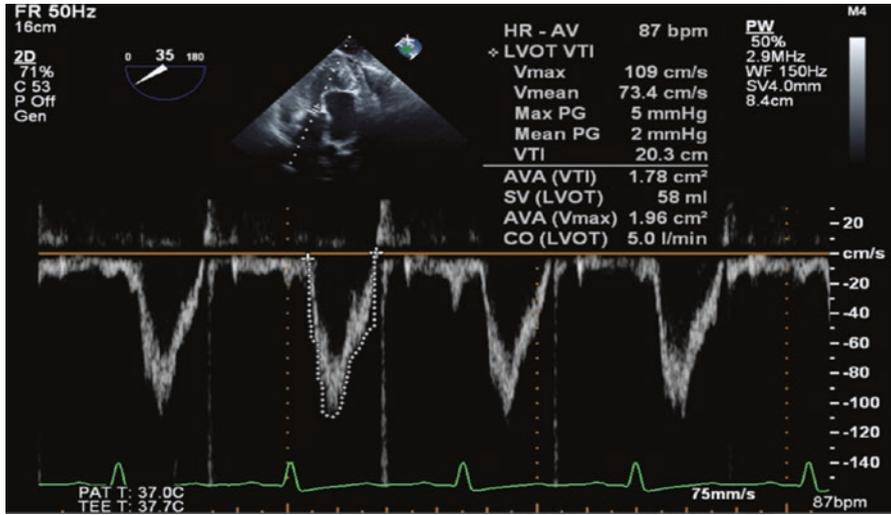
Pulse wave Doppler through the left ventricular outflow tract (LVOT). V_{max} = maximum velocity in LVOT; V_{mean} = mean velocity in LVOT; max PG = maximum pressure gradient in LVOT; mean PG = mean pressure gradient; VTI = volume time integral; AVA = aortic valve area; SV = stroke volume; CO = cardiac output
